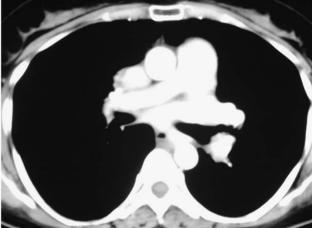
Contrast-enhanced computed tomography of the chest shows enlarged main pulmonary artery (left) and decreased size of the right pulmonary artery (right) compared to the left.
